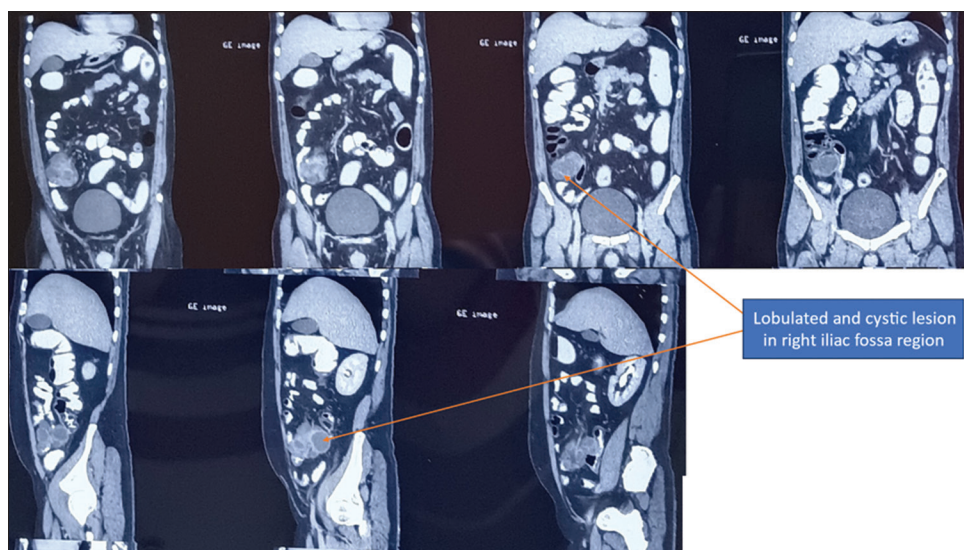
Contrast-enhanced computed tomography abdomen coronal and sagittal section showing cystic lobulated lesion in right iliac fossa
